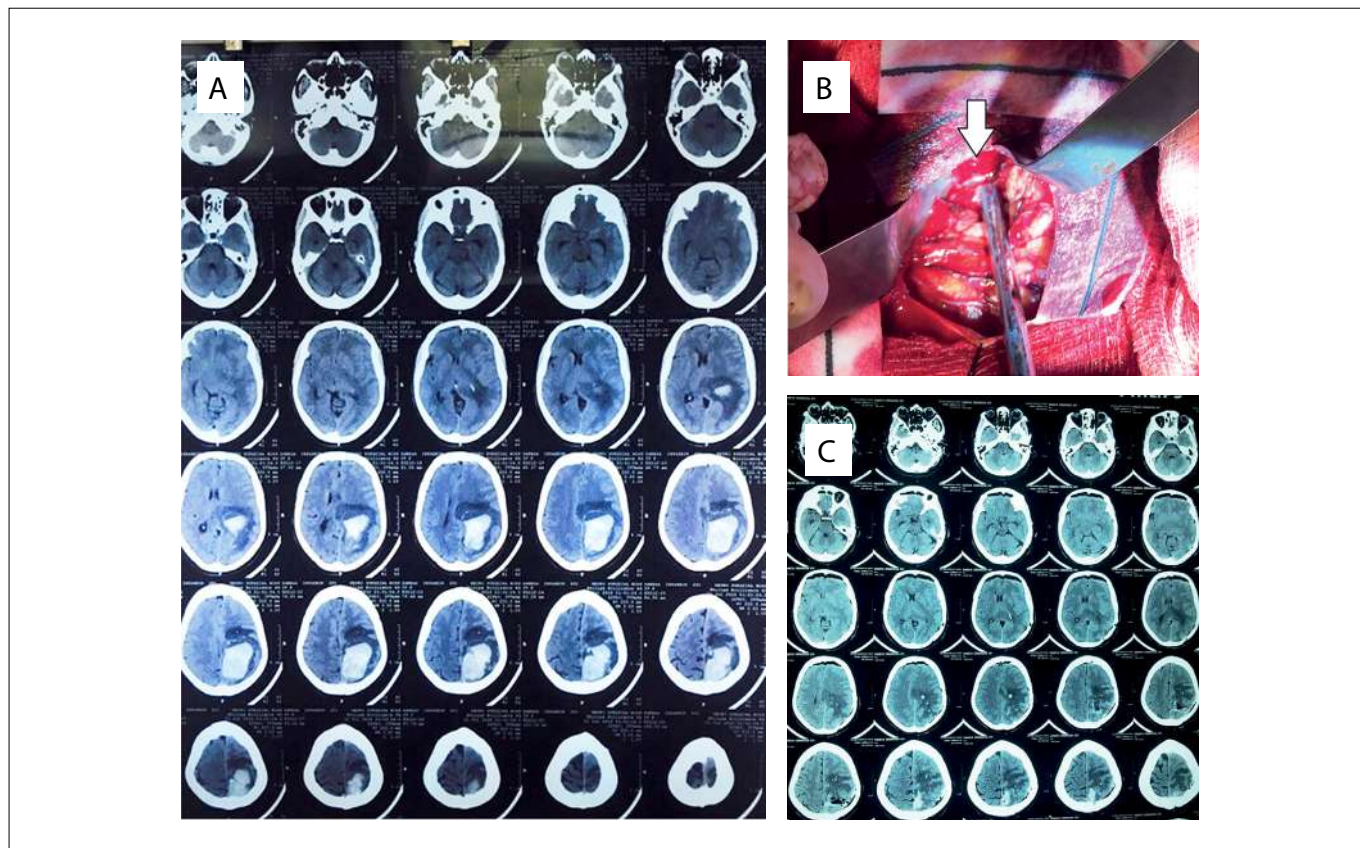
(A) Computed tomography (CT) scan images of the patient's brain, showing metastatic hemorrhagic mass lesion before the cranial surgery. (B) Intraoperative photo showing the hemorrhagic mass (white arrow). (C) Immediate postoperative brain CT scan, showing removal of the lesion with relative reversal of mass effect.
